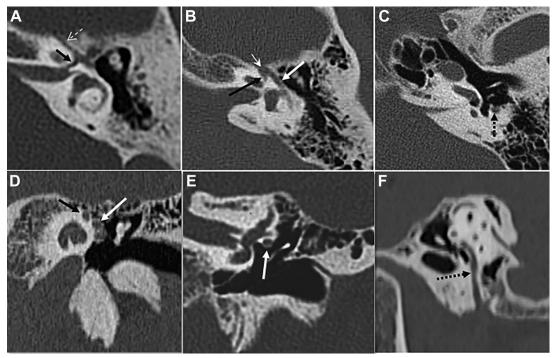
Segments of the facial canal seen on axial (A–C), coronal (D, E), and Poschl (F) reformatted CT images. The labyrinthine segment (*black arrows*), the tympanic segment (*white arrows*), and the mastoid segments (*dotted arrow*) with the GG (*short open arrow*). Note the greater superficial petrosal nerve (GSPN) exiting anteriorly from the GG (*dashed arrow in A*).
